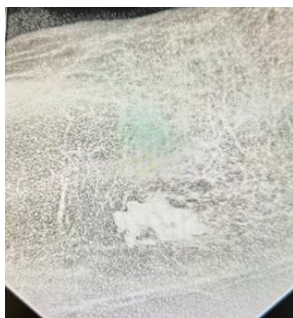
Detection of filling material by targeted X-ray
